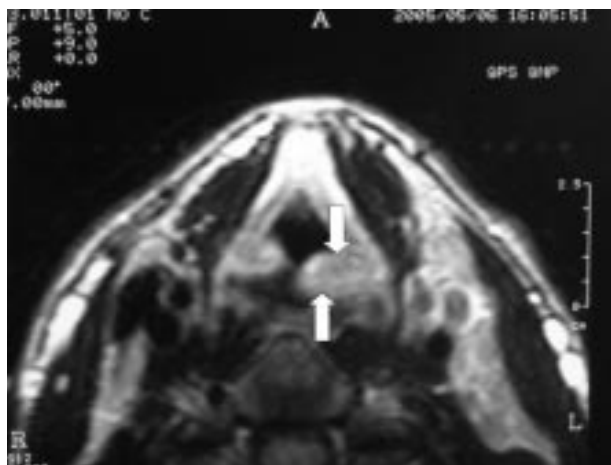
Post-treatment MRI view of the lesion reveals a marked improvement of the lesion. Arrow indicates that minimal edema of the left aryepiglottic fold still persists.
